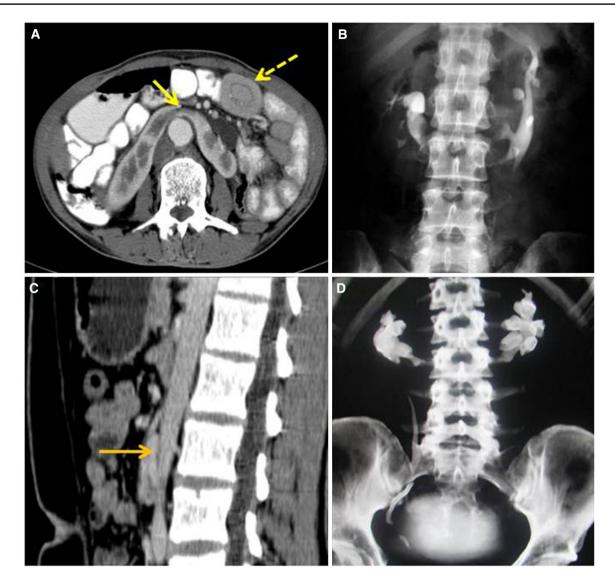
Horseshoe kidney. CT (a) and intravenous urography (IVU; B) images show fusion of the lower ends of both the kidneys across the midline by a parenchymal isthmus (*yellow arrow*). Also note the transient intussusception (*dashed arrow*). A sagittal reformatted (c)
